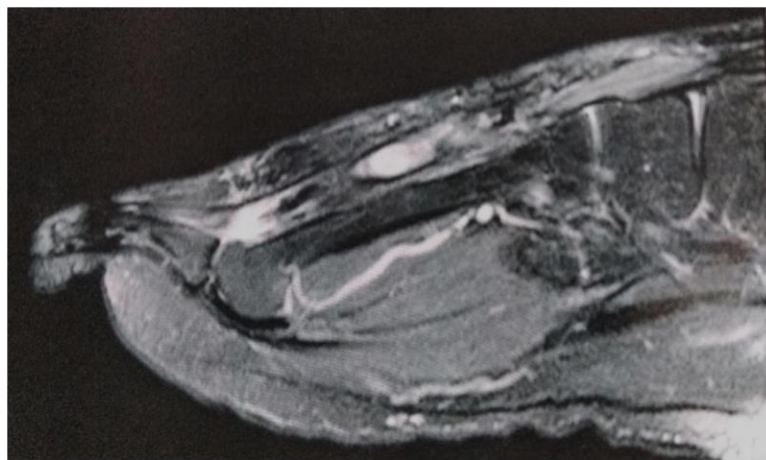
01 year post-operative MRI of the foot
